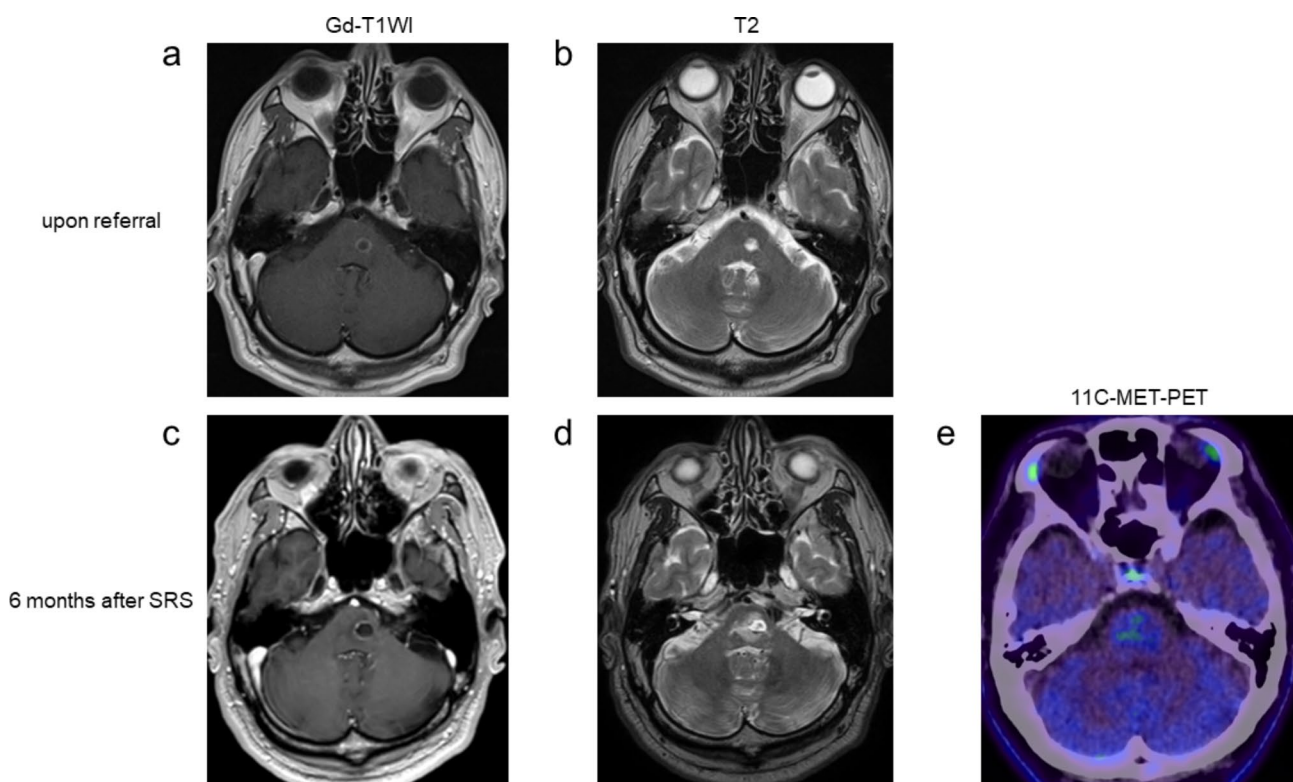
Imaging findings upon referral (panels a, b) and at 6 months post-stereotactic radiosurgery (SRS) (panels c, d, e). (a, c) Brain MRI with gadolinium-enhanced T1-weighted imaging (Gd-T1WI) shows (a) a ring-shaped 6 mm nodule on the left side of the pons upon referral, and (c) an enlargement of the nodule at the same site, observed at 6 months post-SRS. (b, d) T2-weighted MRI displays (b) high signal intensity of the nodule without accompanying edema upon referral, and (d) a water-like signal intensity surrounding the enlarged lesion in the pons, indicative of edematous change due to radiation necrosis (RN), at 6 months post-SRS. (e) No significant 11 C-methionine (MET) uptake in the irradiated lesion of the pons at 6 months post-SRS.
